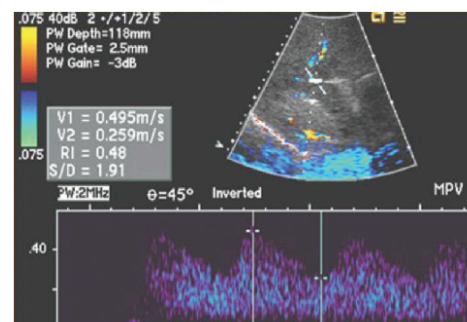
Portal vein thrombosis (malignant tumor thrombus). On a spectral Doppler US image, the color Doppler image shows echogenic material in a distended main portal vein without color flow. Tumor thrombus tends to enlarge veins; however, acute thrombus may do this as well. The spectral waveform is pulsatile, a finding that is abnormal in the portal vein. In fact, the pulsatility of this waveform resembles that seen in arteries; hence the term *arterialization* (of the portal venous waveform). This finding is specific for malignant tumor thrombus.
